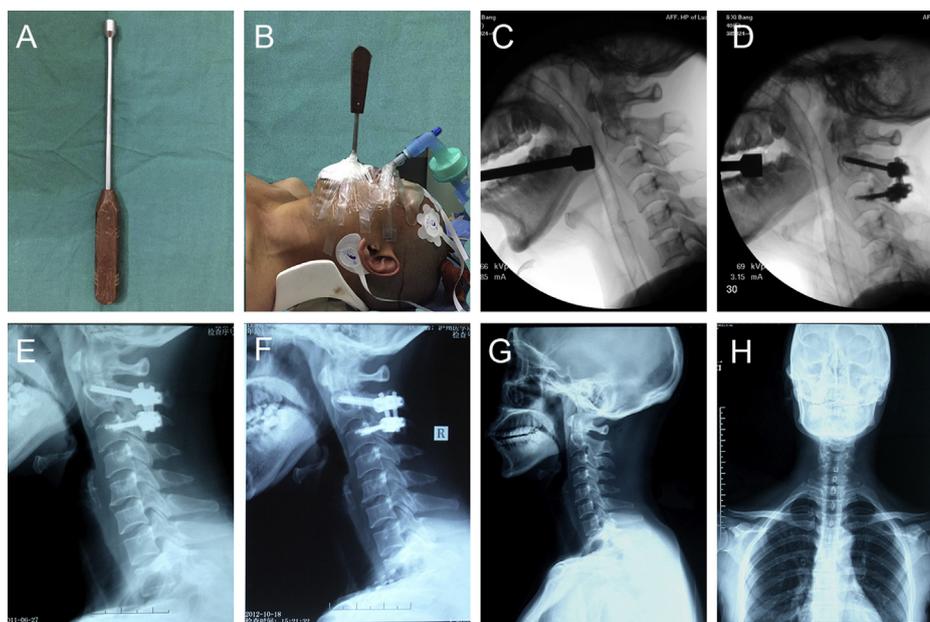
A 40-year-old female with a type II hangman's fracture. A. A bucking bar. B. The bucking bar was placed in the posterior pharyngeal wall and temporarily fixed. C. The head of the bucking bar was placed in front of the axis vertebral body via the mouth after anesthesia. D. C2 pedicle screw-threaded lag screw fixation was performed with the assistance of the bucking bar. E. The C2 pedicle was healed at 3 months postoperatively. F. A large amount of callus formation was observed in the C2 pedicle 2 years after the operation. G (lateral radiograph) and H (posteroanterior radiograph): The C2 pedicle achieved anatomic bony fusion after the removal of the internal fixation.
